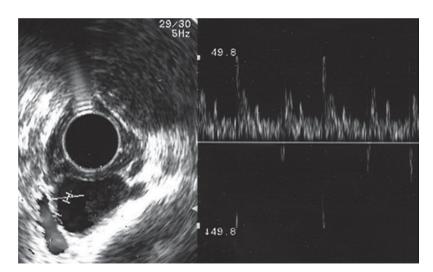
Doppler waveform of aneurysm
